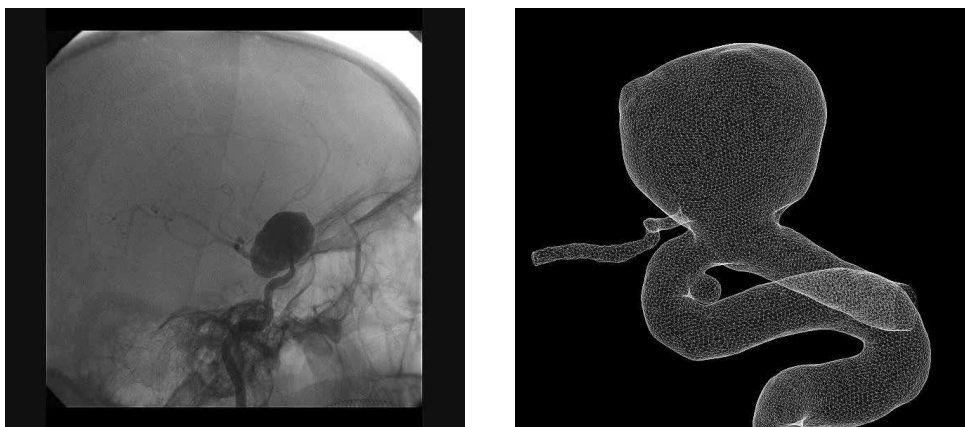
Left: X-rays image of an aneurysm along an ICA; the artery, with its siphon, is clearly visible in the image. Right: image reconstruction of an ICA with aneurysm (different subject with respect to left panel).
